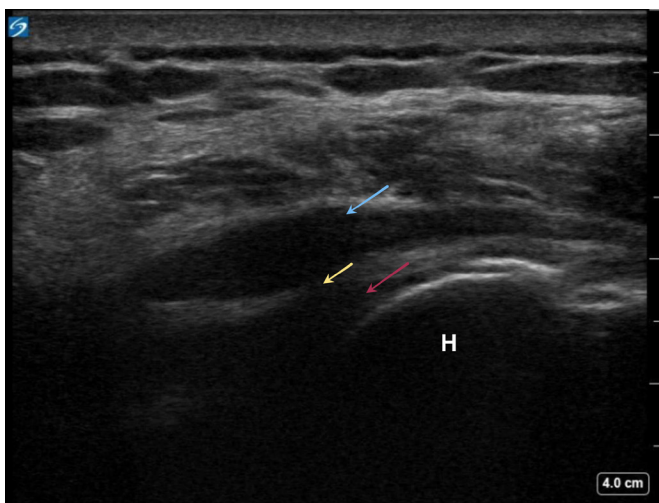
Ultrasonography evaluation of the right subdeltoid bursa. Position 4 from the Jacobson 5-position shoulder protocol revealing a distended hypoechoic subdeltoid bursa (blue arrow), a glenohumeral joint effusion (red arrow) and a communication between these two fluid collections suggesting an infraspinatus rotator cuff tear (yellow arrow). The humeral head is also identified in this image (H).
